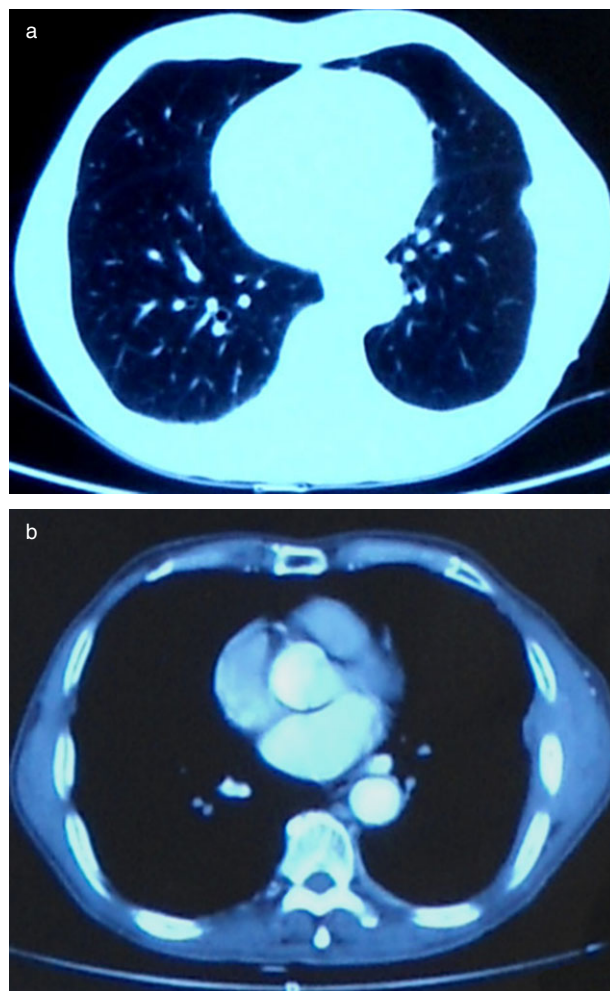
After drainage of pleural effusion, computed tomography demonstrates (a) left pleural thickening, nodular changes, and (b) no enlarged lymph nodes in the mediastinum.
